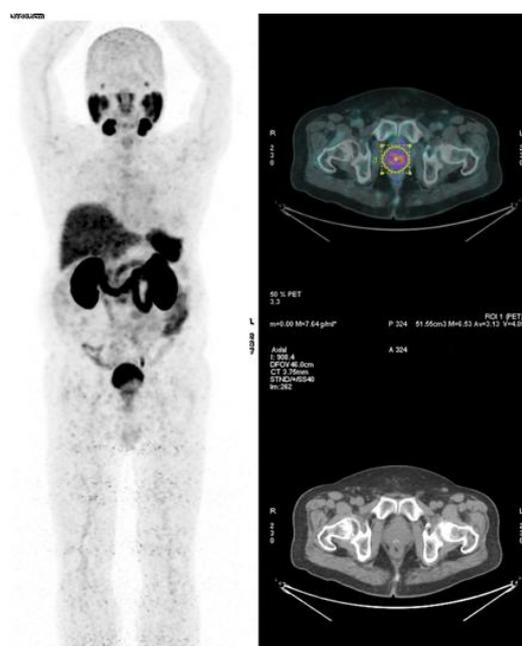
⁶⁸Ga-PSMA PET/CT.
